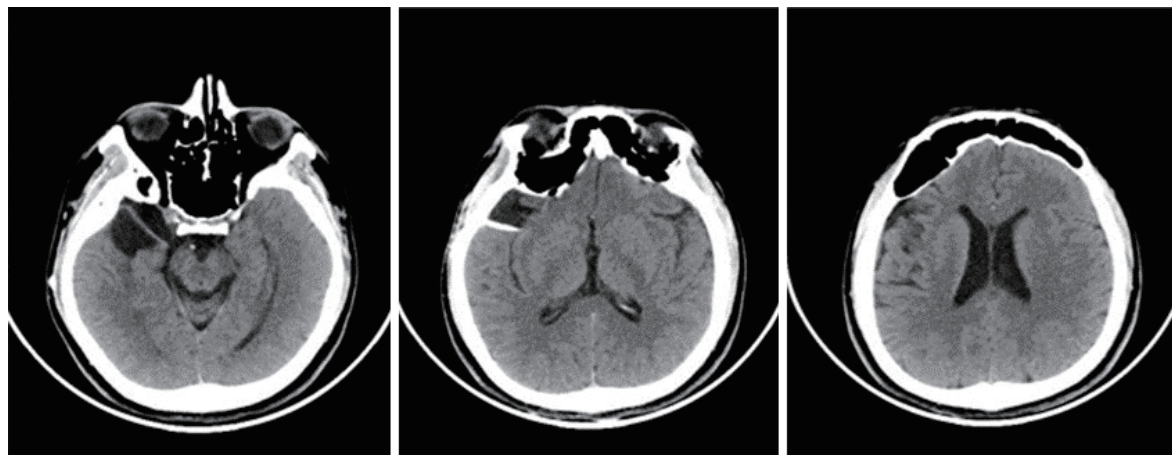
CT demonstrated a collapsed intracranial arachnoid cyst, simple cystic lesions, and isodense to CSF. The intra-cystic catheter of the CP shunt was in it. The ventricle was normal-sized.
